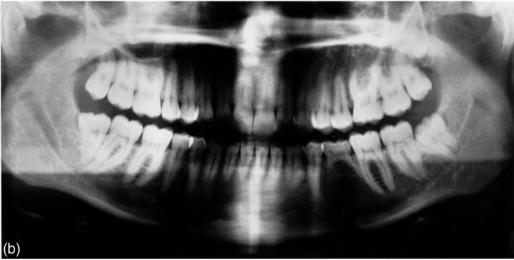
Two orthopantomograms of the same female patient (a) 8 years 5 months, and (b) 26 years 10 months. (a) At the early mixed dentition stage before puberty agenesis of the lower left second premolar was diagnosed. After orthodontic evaluation of the occlusion it was decided to allow the deciduous molar in the agenesis region to persist as a semi-permanent solution. Minor resorption of the medial root of the deciduous molar was observed. (b) Eighteen years after the first orthopantomogram (a), the root length of the deciduous molar seems to be unchanged. The permanent dentition appears without malformations and with long roots.
